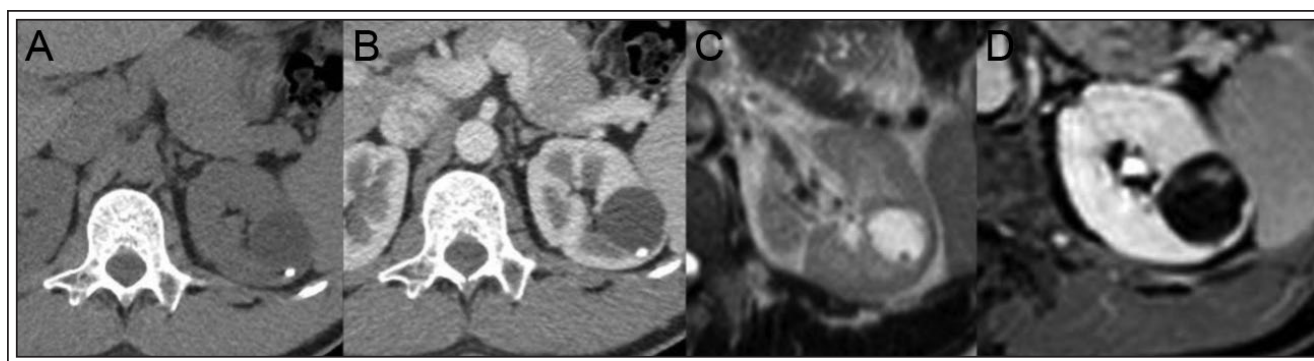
Axial CT pre (A) and post-contrast IV (B), showing a cystic lesion in the left kidney with a small calculus inside. C) axial T2wi, same cystic lesion with homogeneous liquid content. D) T1wi excretory phase after IV contrast injection, the cystic lesion with minimally thickened septum.
